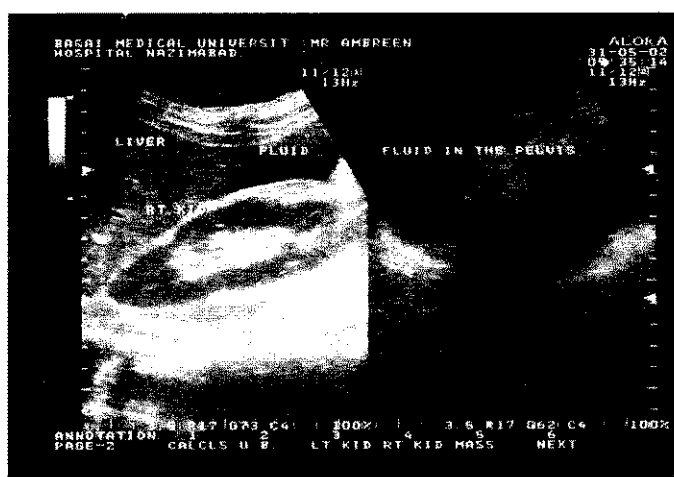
b: Ultrasound showing fluid in pelvis.
